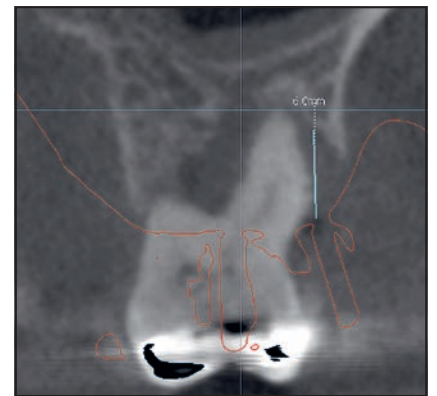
Example case 2. (a) Clinical view before extraction. (b) CBCT scans show advanced bone loss around a first molar. (c) Clinical view of the Ti-d-PTFE membrane in position after tooth extraction. (d) Occlusal view after implant placement. (e) Clinical and (f) radiographic views 6 months after crown placement.
